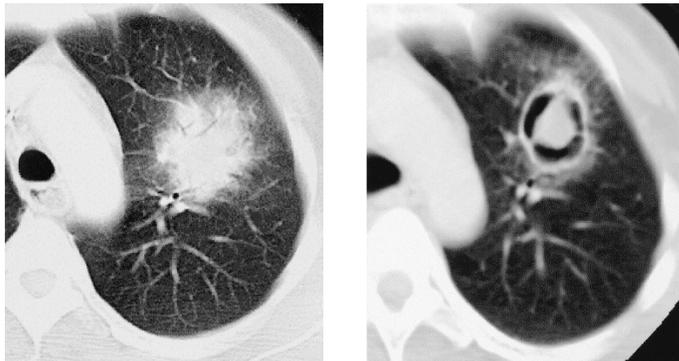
Characteristic halo sign (left) and air crescent sign (right) observed in CT.²⁰
